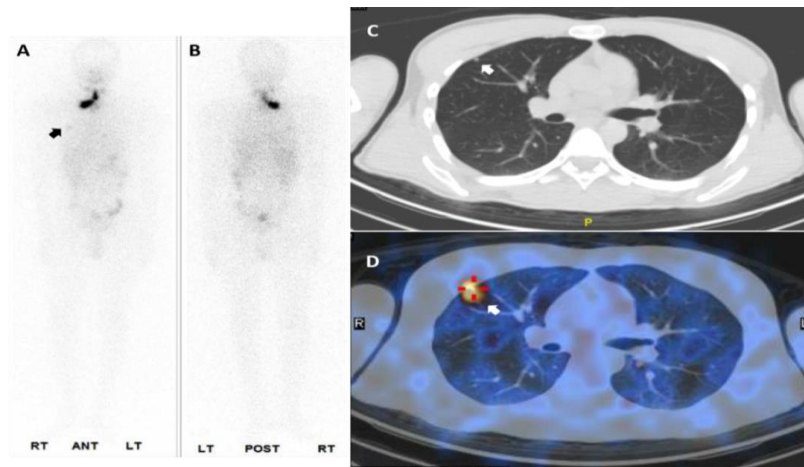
Case 1: 27 years old male with papillary thyroid carcinoma post total thyroidectomy. On WB images (A &B), tracer uptake is seen in thyroid bed together with small faint activity in right anterior chest (black arrow). SPECT/CT imaging (C & D) revealed a tiny pleural based metastatic pulmonary nodule in anterior segment of right upper lobe with significant activity.
